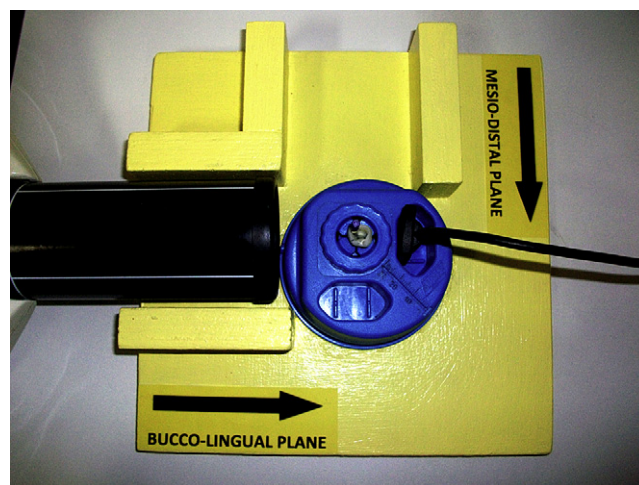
Experimental apparatus during radiographic measurements. (This figure is available in color online at www.aae.org/joe/.)
